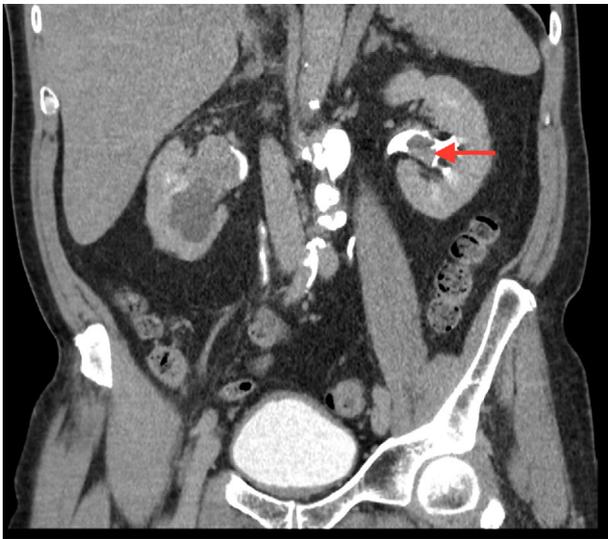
CT urogram of urothelial cancer.
